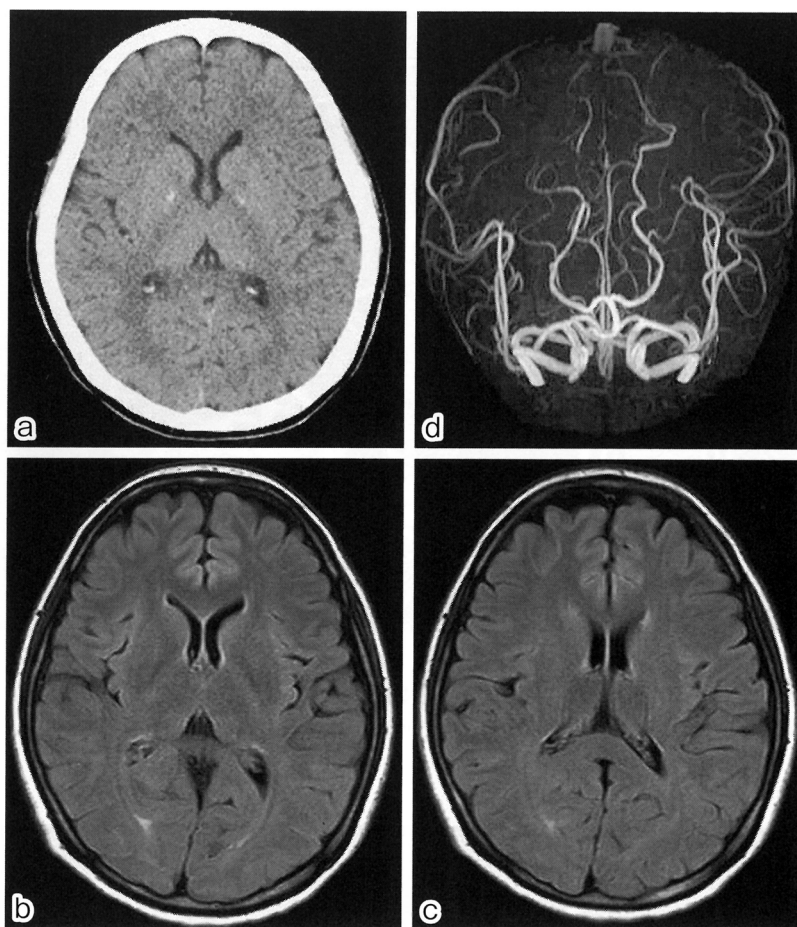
発症 10 時間後頭部単純 CT・頭部 MRI
